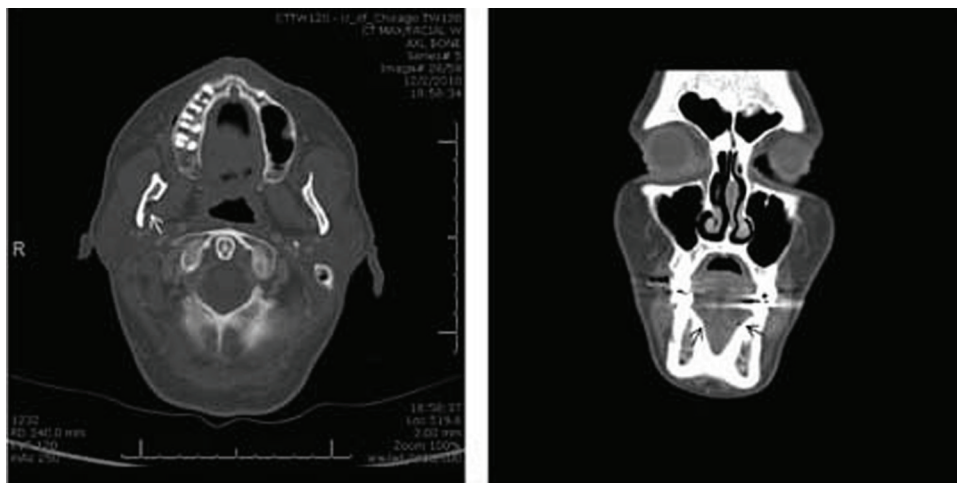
Axial section (left panel) and coronal section (right panel) of maxillary/facial CT scan with contrast showing no evidence of bony metastasis in the mandible. Note the relatively larger right-side mandibular foramen (white arrow), which could be normal anatomical variation or lesion. Also note the intact bilateral mental foramen (black arrows).
